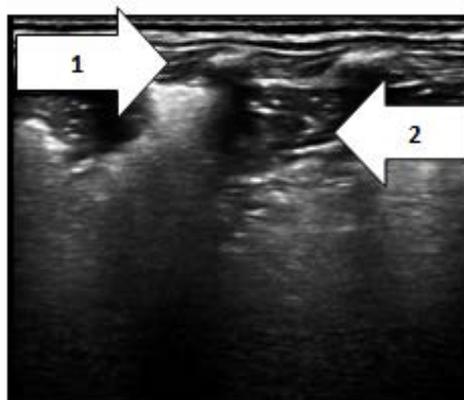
Chest ultrasound for neonatal pneumonia patient showing deformed pleural line (Arrow 1) and irregular consolidations with air bronchogram (Arrow 2).
